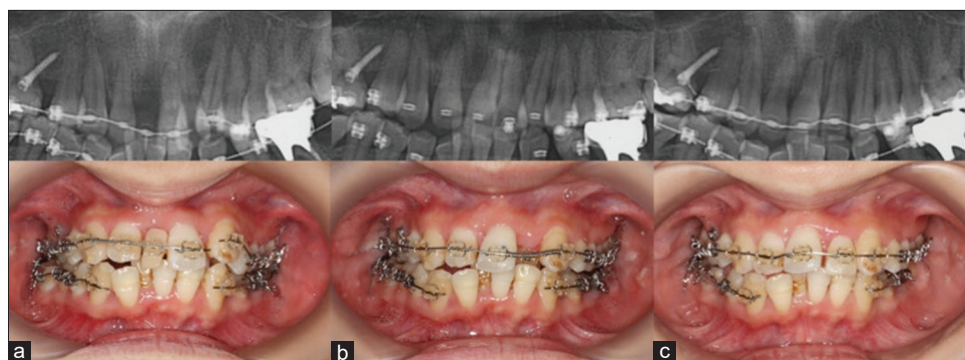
Intraoral photographs and panoramic radiographs showing treatment progress after (a) 3 months; (b) 7 months; and (c) 12 months.
